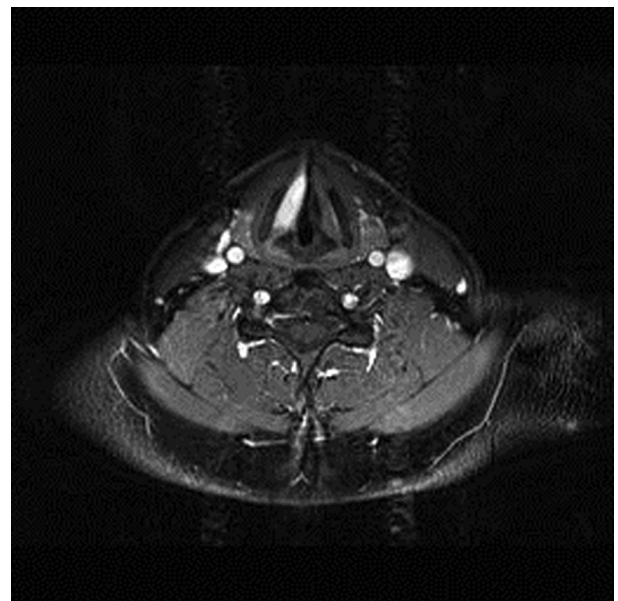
MRI GRE postcontrast of the true vocal folds.
